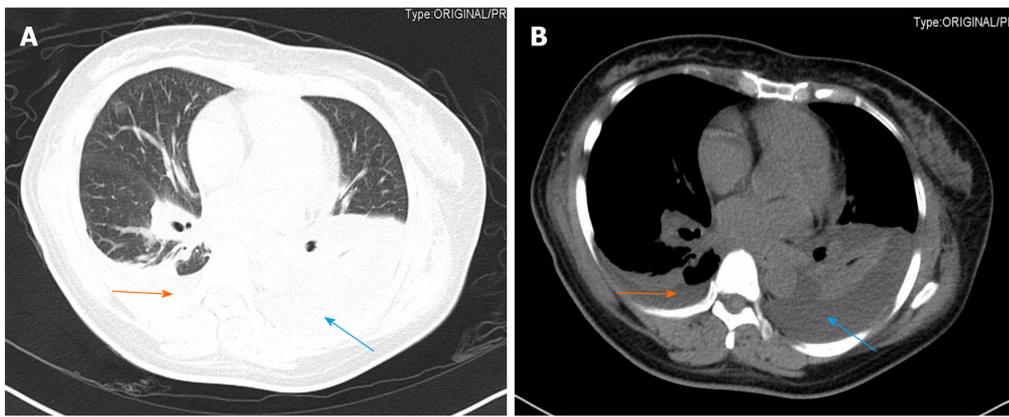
Chest computed tomography of postoperative day 6. Right-sided small amount of effusion (orange arrow) and left-sided moderate amount of effusion (blue arrow). A: Right hemithorax; B: Left hemithorax.
